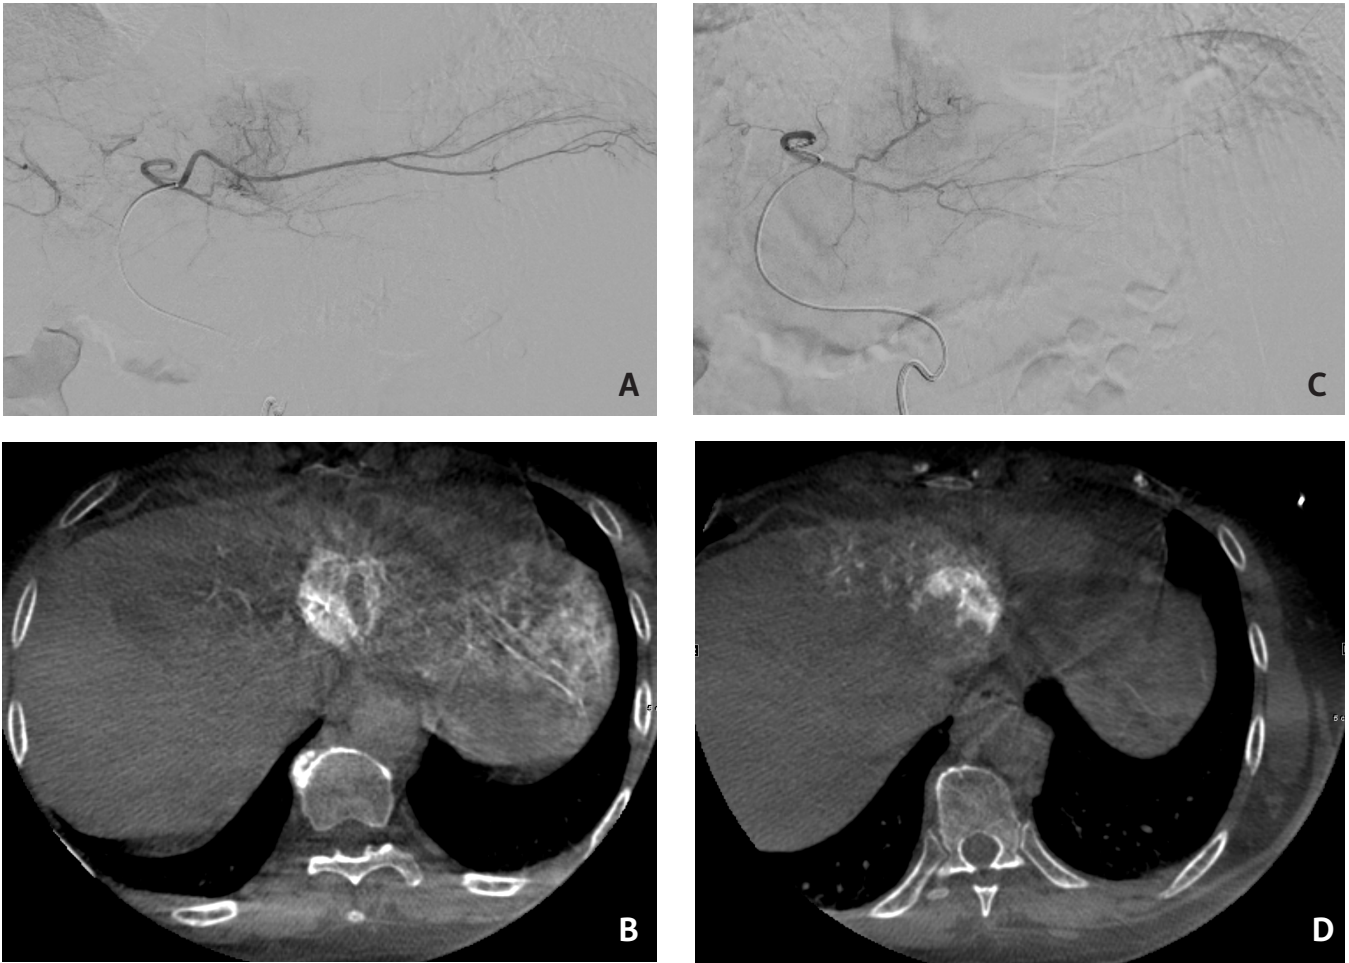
Patient with hepatocellular carcinoma (HCC) in the left lobe supplied by segment 2 and segment 3 arteries. (A) Digitally subtracted angiogram (DSA) image showing supply of the tumor by the segment 2 artery. (B) Cone-beam CT (CBCT) image showing that the segment 2 artery supplies predominantly the right and posterior portions of the tumor. (C) DSA image showing supply of the tumor by segment 3 artery. (D) CBCT image showing that the segment 3 artery supplies predominantly the left and anterior portions of the tumor.
